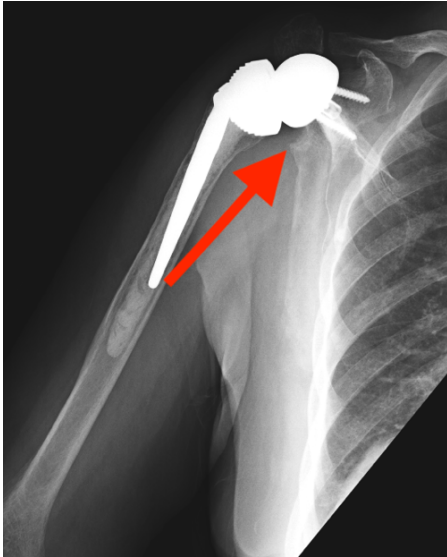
25-month control anteroposterior radiograph of a 78-year-old patient with an RSA for rotator cuff arthropathy. Scapular notching is indicated by the arrow
